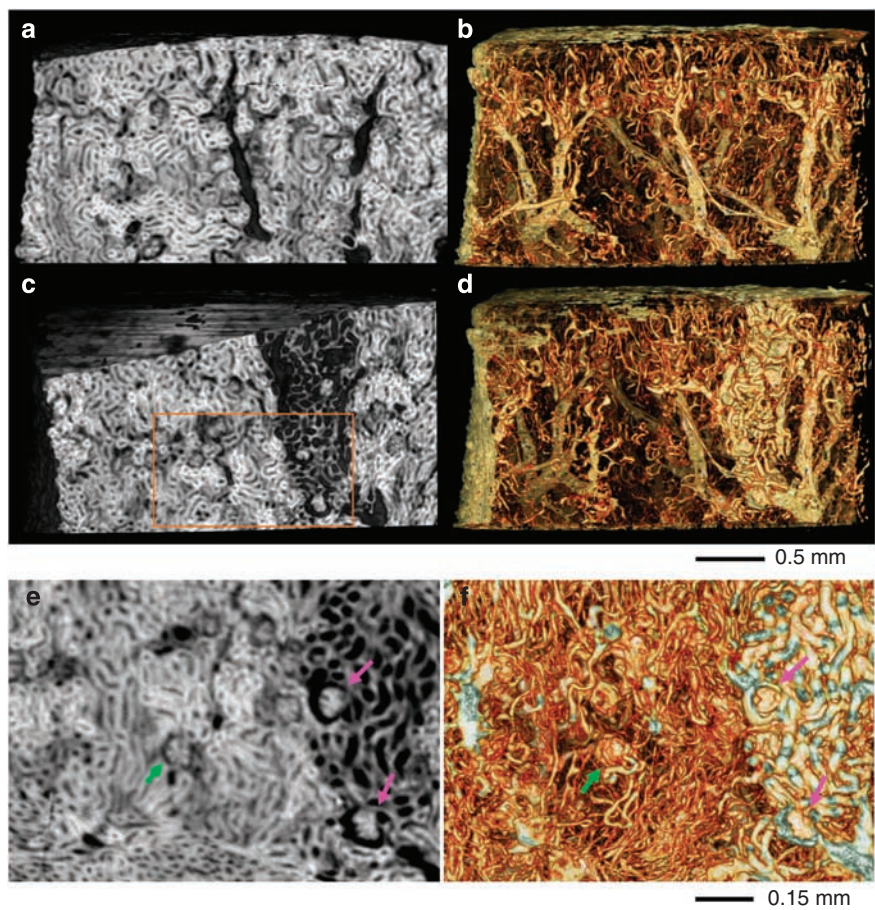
Image of renal microstructure and vasculature obtained by X-ray phase contrast microtomography. (a and c) X-ray phase-contrast microtomogram of renal cortex and (b and d) three-dimensional extracted renal microvasculature and tubule of normal and abnormal area in an APA hamster. (e and f) The magnified images are from the rectangular area in Figure 1c. Distribution of the renal arteries and veins was visualized successfully. The capillary tufts are observed clearly in normal glomerulus (green arrows), whereas the widening of Bowman’s space and the indistinct pattern of the capillary loop are observed in abnormal glomerulus (pink arrows). In the three-dimensional image, non-dilated tubules and non-atrophic glomeruli are shown in normal cortical areas, whereas dilated tubules and atrophic glomeruli are depicted clearly in the FSGS lesions.
